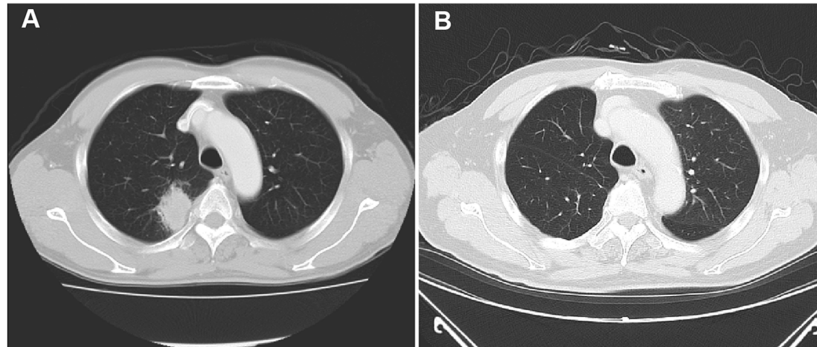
Chest CT examination. (A) A chest CT performed in July 2005 revealed a 4-cm tumor in the upper lobe of the right lung. (B) A chest CT performed in December 2020 revealed no signs of tumor recurrence.
